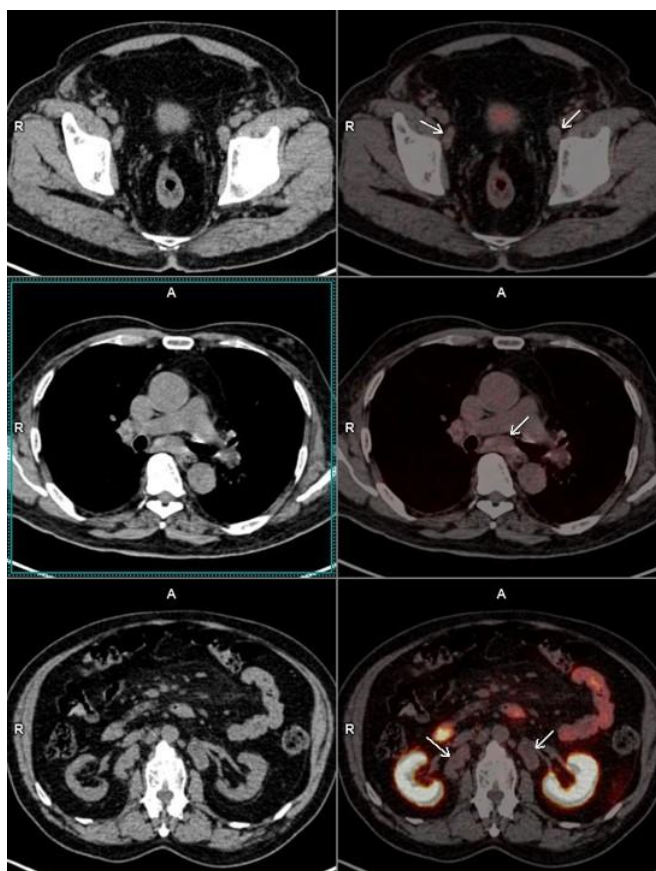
PSMA PET-CT showing multiple large non-avid lymph nodes in the iliac, paraaortic and mediastinal regions suspicious of primary neoplastic aetiology.
